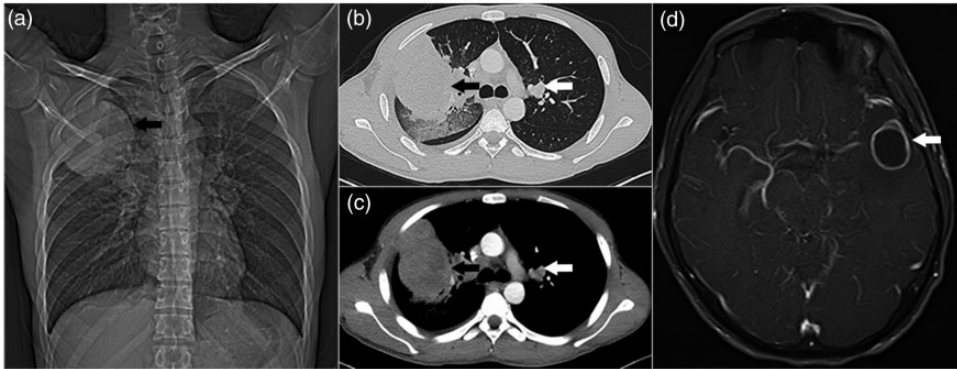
(a) Chest X-ray showed a large mass (black arrow); (b and c) Chest computed tomography (CT) scan showed a mass (10.2 x 7.2 cm, black arrow) in the right upper lung with several nodules (white arrow); (d) Brain magnetic resonance imaging (MRI) showed ring-enhancing intracranial lesions (white arrow).
